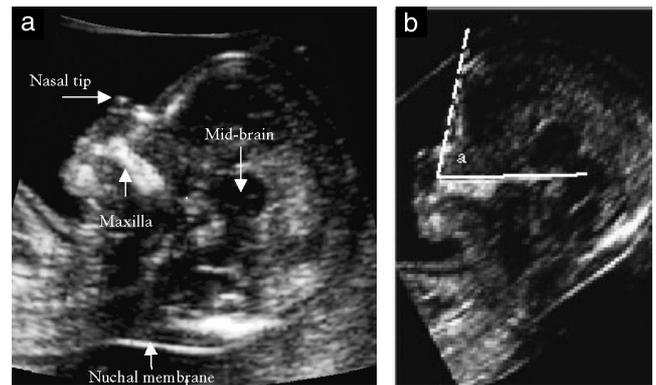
Ultrasound image in the mid-sagittal plane of the fetal profile, demonstrating the tip of the nose, the translucent mid-brain, the nuchal membrane and the rectangularly shaped maxillary bone (a). The frontomaxillary facial (FMF) angle is defined by a line along the upper surface of the maxilla and a line that traverses the upper corner of the anterior aspect of the maxilla and extends to the external surface of the frontal bone (b).
